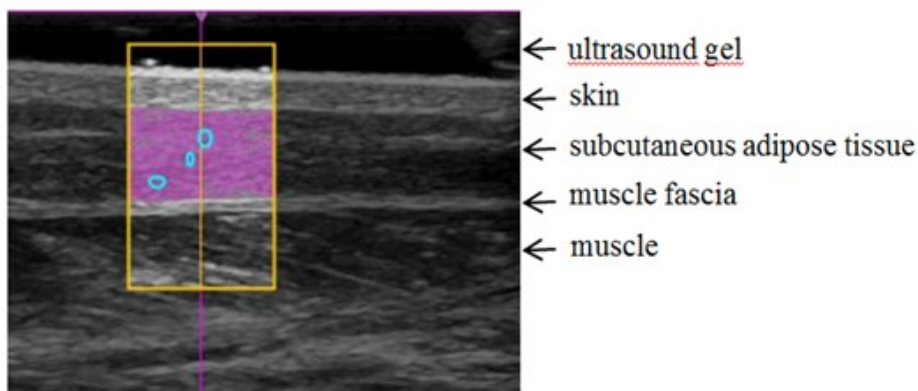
shows an example of ultrasound image of the subcutaneous adipose tissue.
